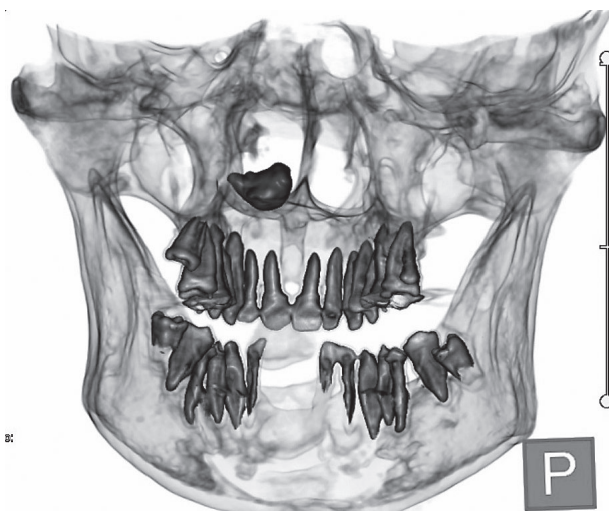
CT – reconstruction of teeth and foreign body in nasal area from Figure 5.
